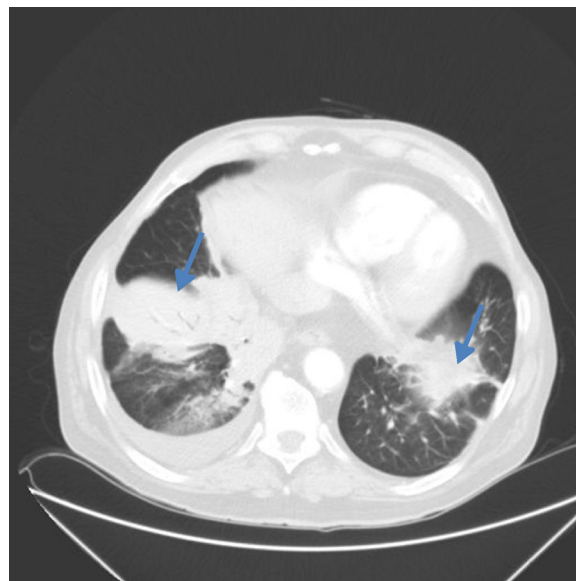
Lung computed tomography showing bilateral pulmonary infiltrates (right lung base and left lower lingula) with bronchoalveolar pattern and right pleural effusion.
